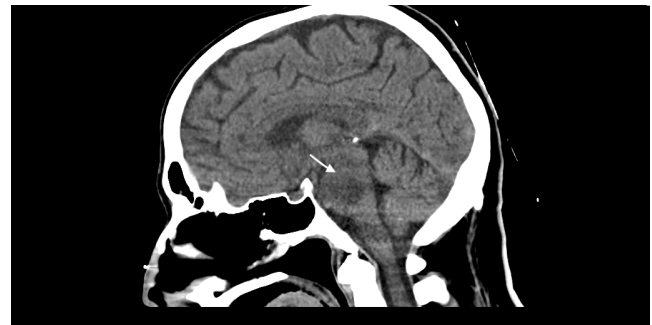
Hypodense, non-enhancing lesion in sagittal sequence, CT image of CPM (white arrow)
